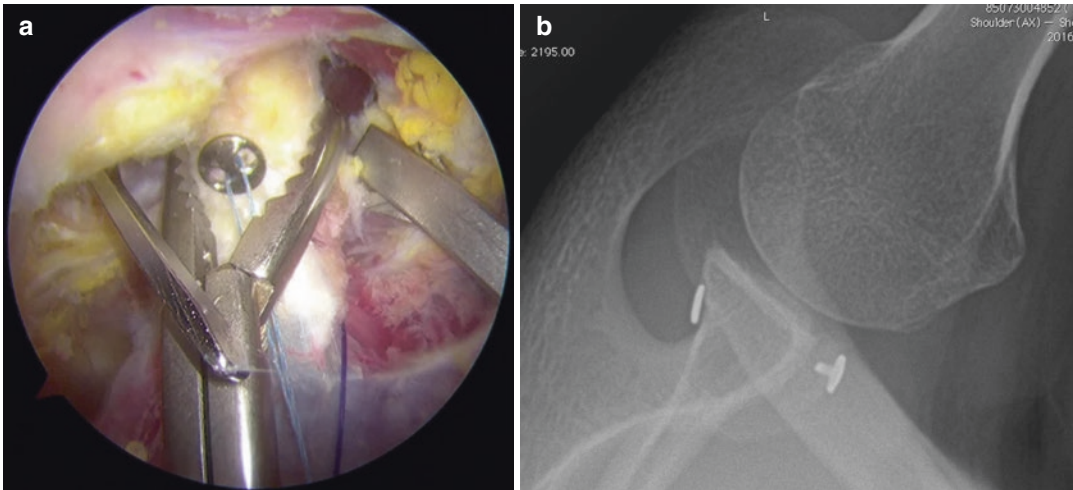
Arthroscopic Coracoid transfer (Latarjet-Bankart) with endobutton fixation and labral repair ((a) arthroscopic picture, (b) postoperative X-ray)
